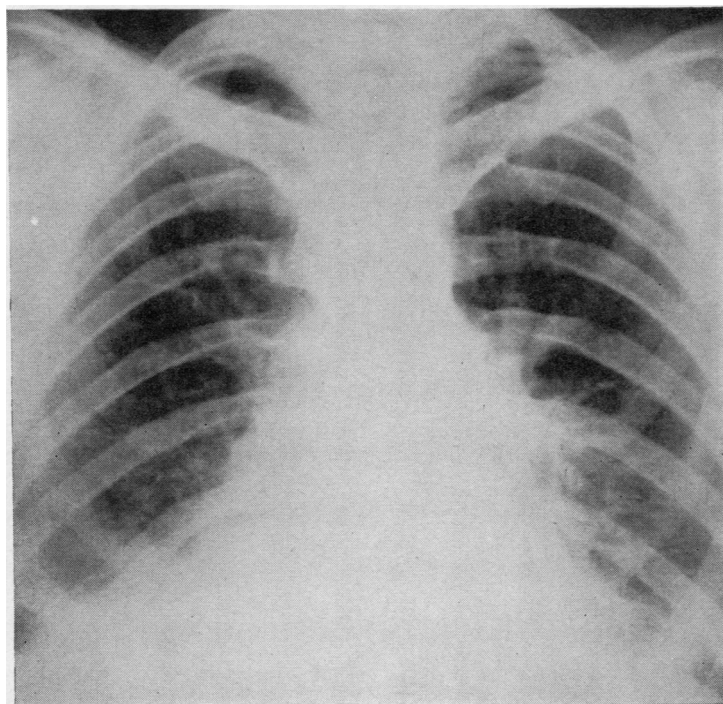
Radiograph of the chest of patient D.B., showing bilateral basal opacities above a somewhat raised diaphragm.
